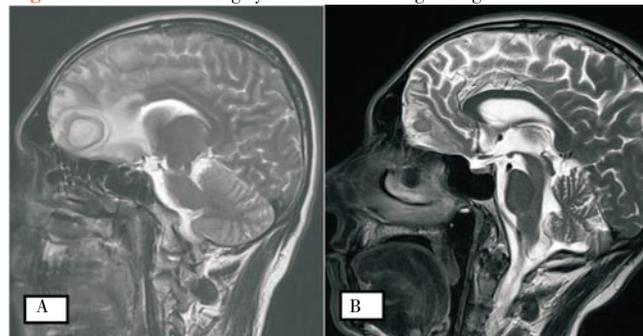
(A): Cranial MRI showing cystic lesion in the right frontal lobe; (B): significant regression of the cystic lesion in the right frontal lobe after two months of albendazole treatment.
